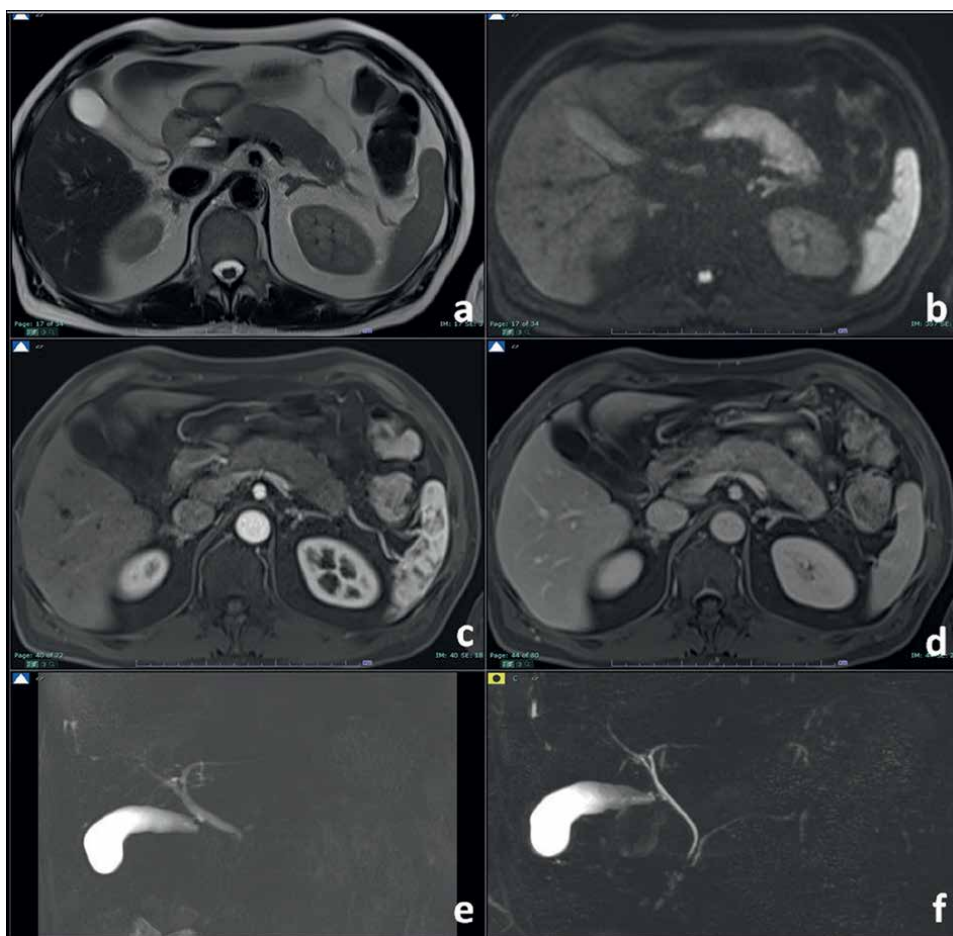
M, 55 yo. Autoimmune pancreatitis, diffuse form. A diffuse enlargement of the pancreas is appreciable (a), showing restricted diffusion with high signal intensity on DWI (b), hypovascular in the arterial phase (c) but showing late homogeneous enhancement (d). At MRCP (e), the Wirsung duct is not appreciable due to the compression from the enlarged pancreas but returns to normal after steroid therapy (f).
